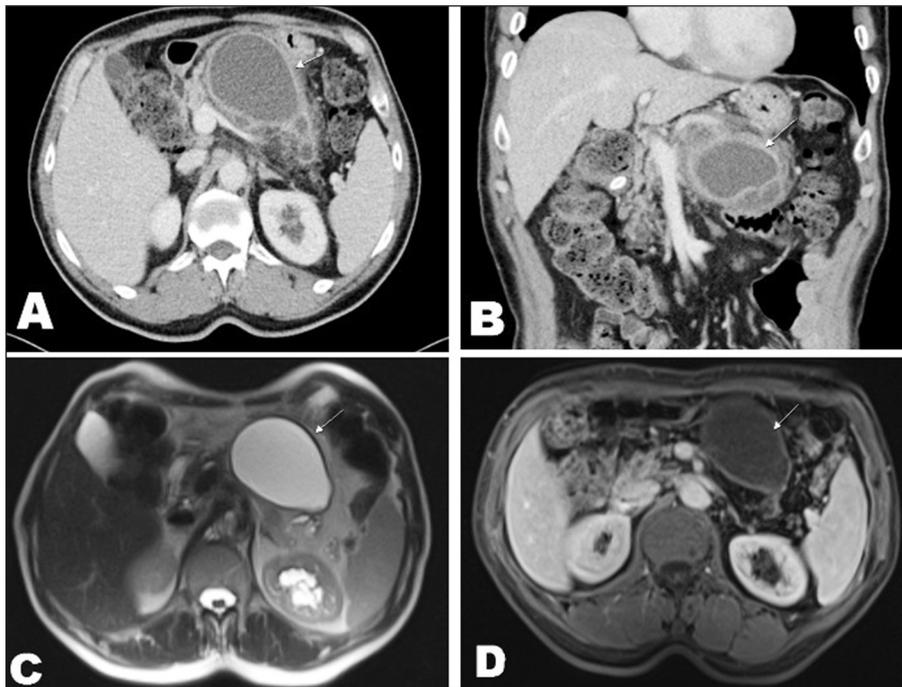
Axial contrast-enhanced computed tomography scan (A) and coronal contrast-enhanced computed tomography scan (B) show cystic mass with septations and thick wall in the corpus of pancreas (yellow arrow). Axial T2-weighted fat-saturated magnetic resonance imaging scan (C) and axial contrast-enhanced magnetic resonance imaging scan (D) show cystic lesion in the corpus of pancreas (yellow arrow).
